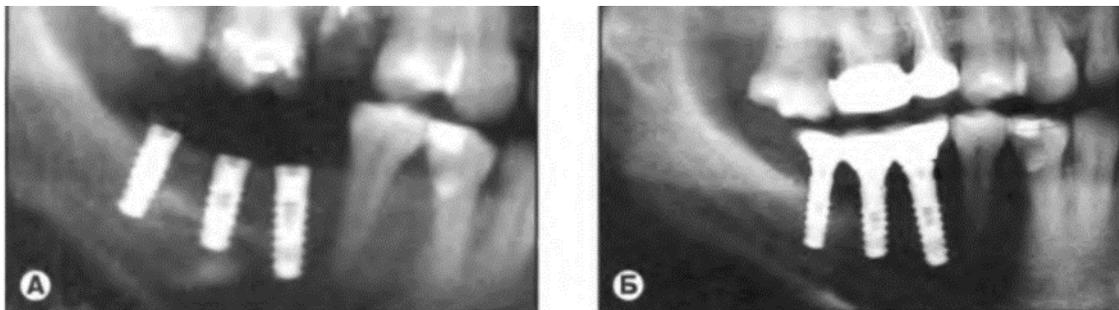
Figure # 3. X-ray of patient S., 35 l. implant area due to inadequate functional load.
